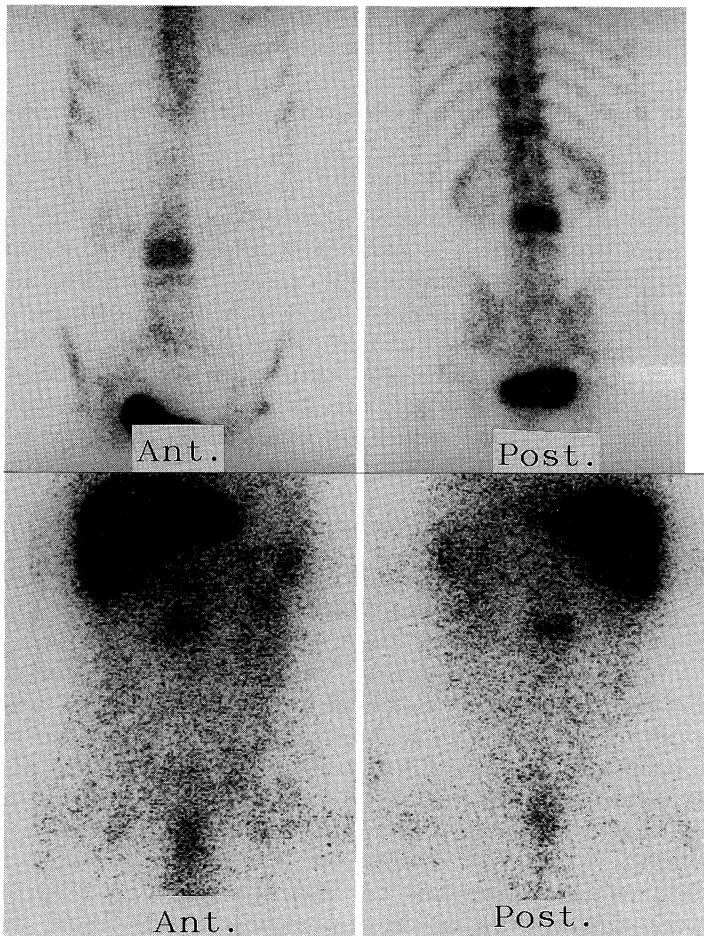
Bone (a) and ^{67}Ga scintigraphies (b) show marked homogeneous accumulation in the third lumbar vertebra. The mildly increased accumulations in lower thoracic vertebrae on bone scintigraphy are due to old compression fractures.
